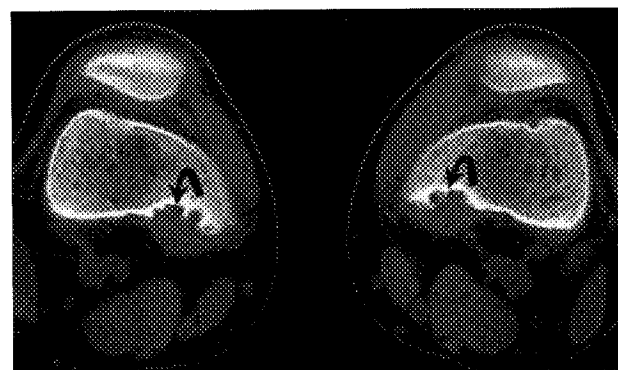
Twelve-year-old female with bilateral knee pain. Oblique knee radiograph (A) shows a small lytic lesion in the distal medial femoral metaphysis (arrowheads). CT (B) of both distal femoral metaphyses shows bilateral posteromedial cortical defects with irregular concave sclerotic medullary borders and soft tissue attenuation centrally (curved arrows). Axial T1-weighted MR image (C, 500/20) depicts the characteristic posteromedial location with low-signal, well-defined border and intermediate signal centrally (arrows).
